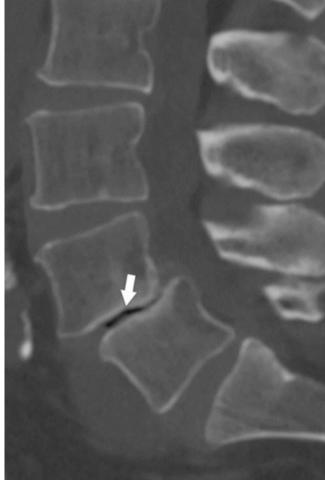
Sagittal computed tomography (CT) of the lumbar spine showing degenerative changes with disc height loss at L4–L5. Also note intradiscal gas (arrow). (Reprinted by permission from Springer Nature: Imaging of Degenerative Disk Disease by Guillaume Bierry, Jean Louis Dietemann. Copyright 2016)
